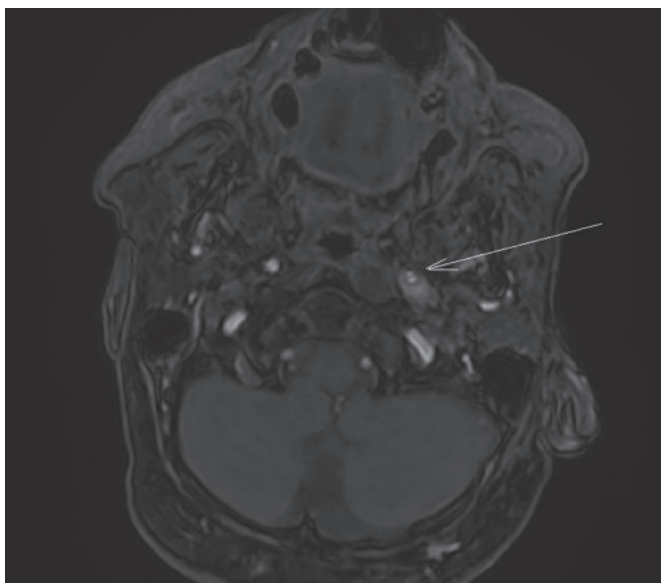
MRI sequences TOF. Intramural hematoma at dissection level and narrowing of arterial lumen.
